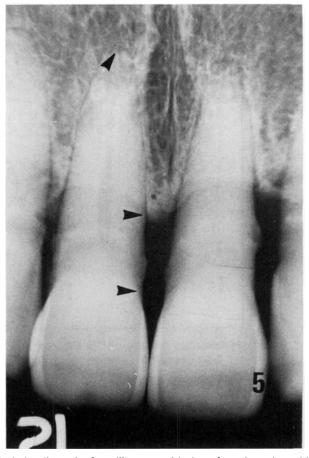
Periapical radiograph of maxillary central incisors from the patient with lepromatous leprosy shown in Fig. 2. The landmarks used to measure alveolar bone loss are indicated by arrows. Alveolar bone loss in this patient was 32.5%.
